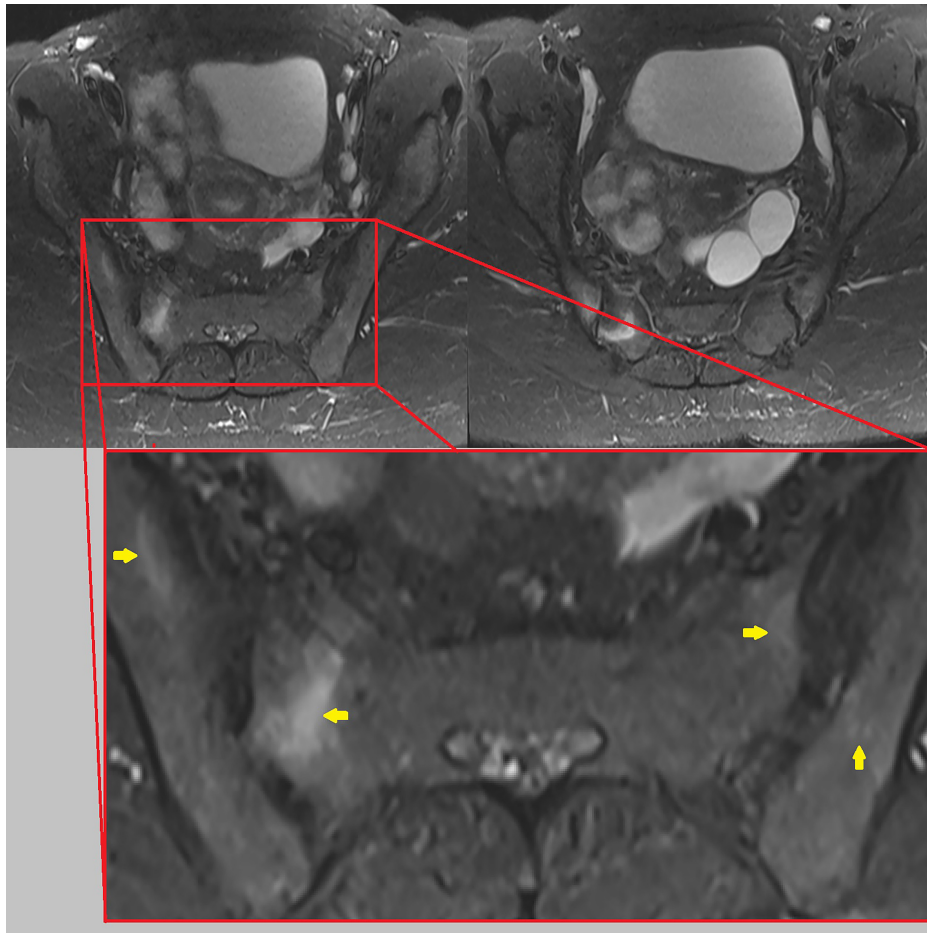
T2-weighted axial plane short tau inversion recovery (STIR) images reveal the subchondral and medullary edema in both sacroiliac joints with right-sided dominance, and the yellow arrows point to areas of bone marrow edema in the magnified image.
